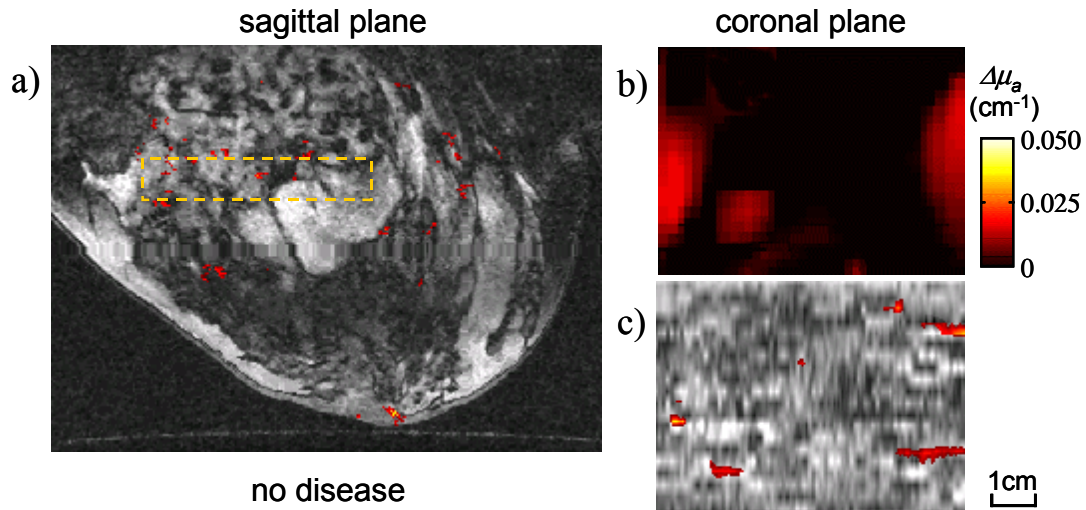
No disease. (case III) *a)* Functional sagittal MR image after Gd contrast enhancement passing through the middle plane of the breast. *b)* Coronal DOT image, perpendicular to the plane of the MRI image in (a), for the *volume of interest* (VOI) indicated on (a) with the interrupted line box. *c)* Functional MR coronal re-slicing of the VOI with the same dimensions as (b).
